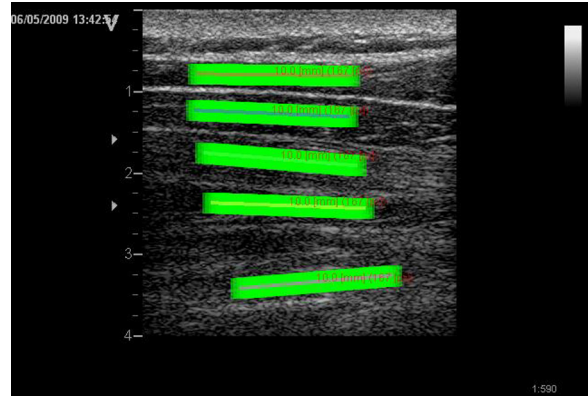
Longitudinal ultrasound image of dorsal neck muscles with regions of interest from superficial to deep: trapezius, splenius, semispinalis capitis, semispinalis cervicis and multifidus.
